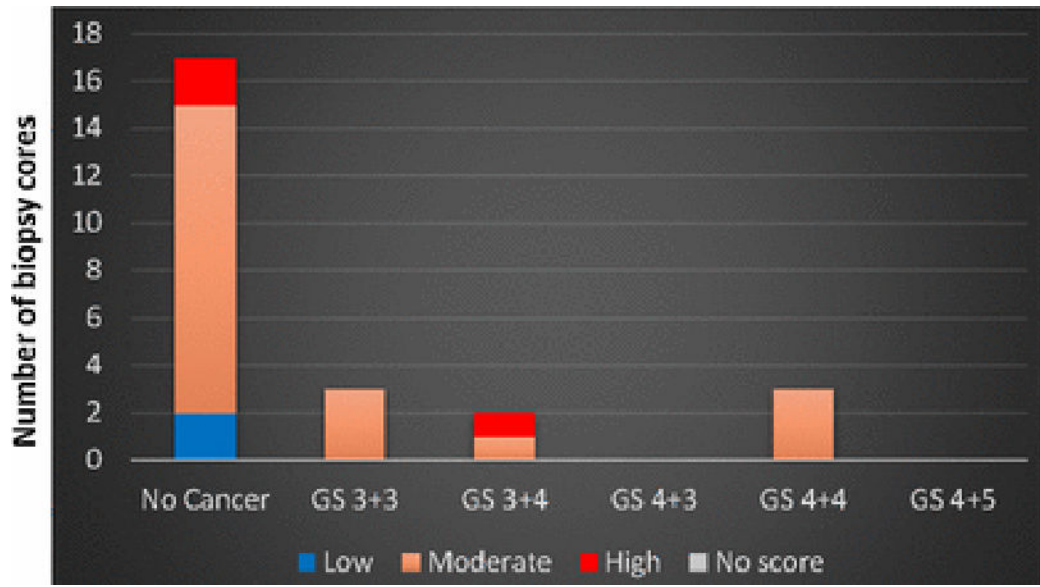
Gleason score distribution and MRI grades of the 25 biopsy cores of data set B used for testing the generated model.
